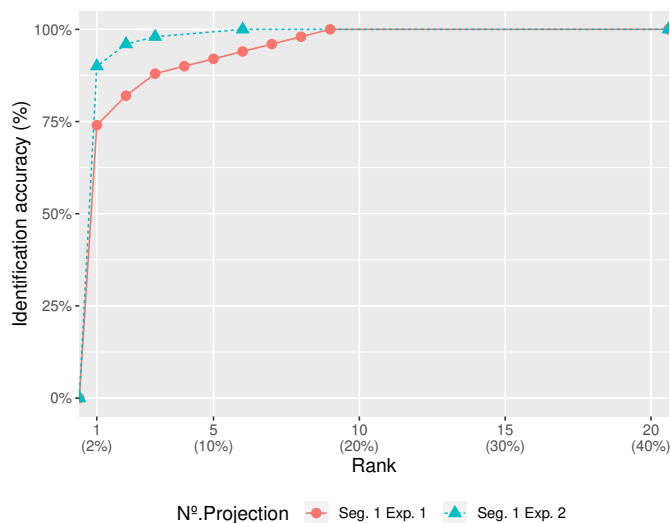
CMC curves of the radiograph inter-expert study (2 segmentations performed by 2 anthropologists; 50×50 comparisons per segmentation)
